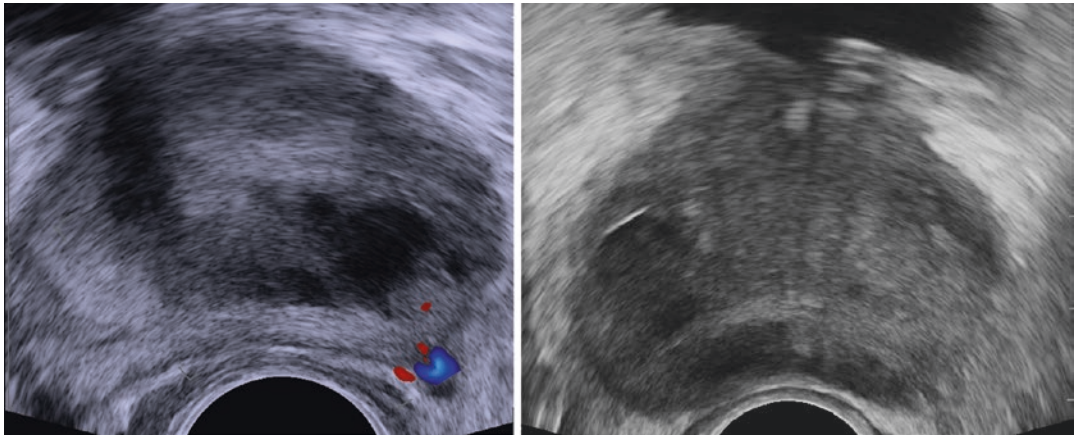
Prostatic abscess: color Doppler ultrasound reveals perilesional vascularity
